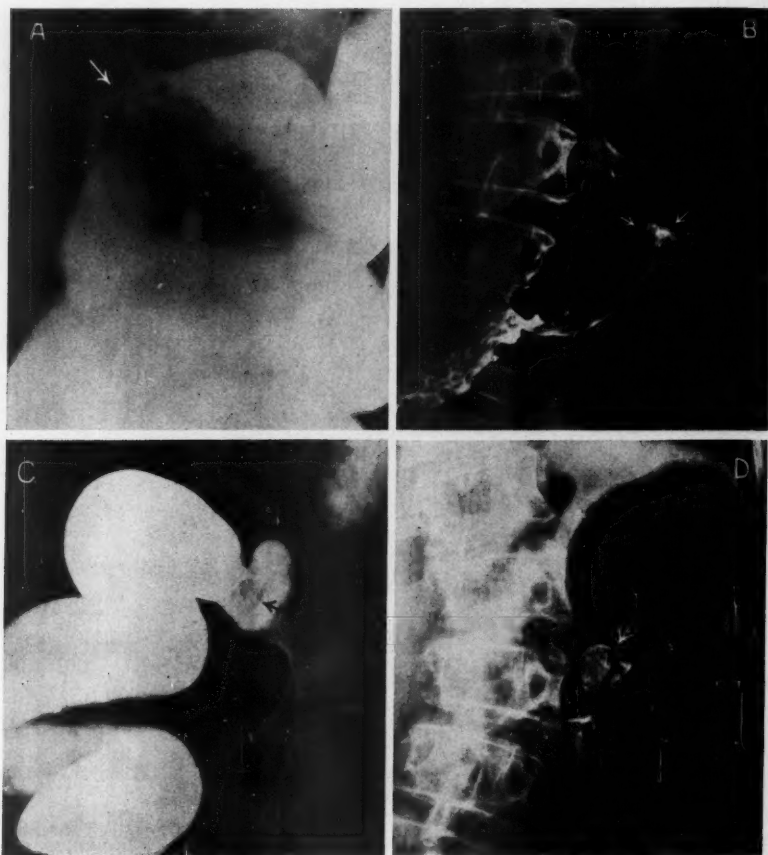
Case 3. A 56 year old white woman was first seen in 1944 because of painless bleeding per rectum. Repeated examinations elsewhere had not shown any disease. The barium enema study showed a large polyp in the lower sigmoid (a) and a smaller polyp just below the splenic flexure (b). This second polyp was overlooked in the interpretation of the roentgenograms. The polyp in the sigmoid was removed and the patient was well for the following five years.
